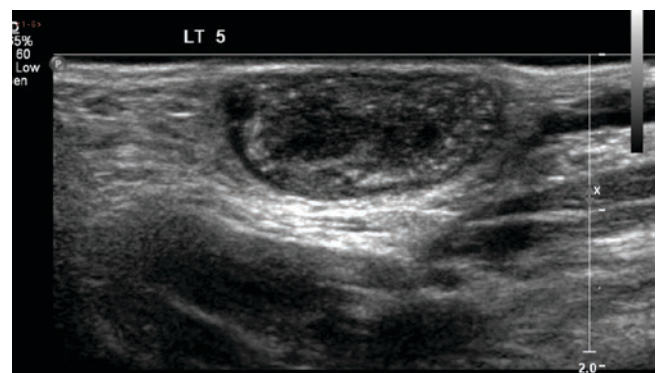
Atypical mycobacterium infection of a posterior cervical lymph node. Longitudinal ultrasound image shows multiple tiny foci of increased echogenicity within the lymph node, consistent with intranodal calcification
